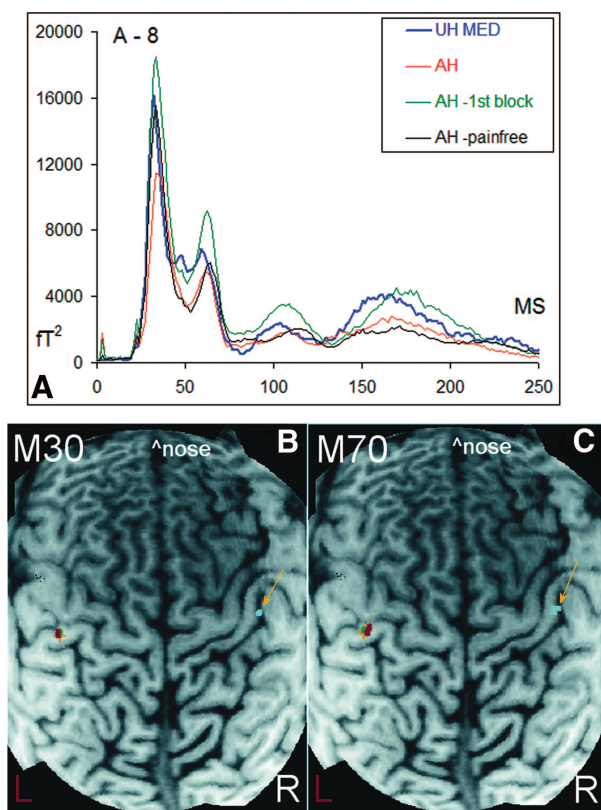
and C present a one-dimensional image of the MRI of patient A-8 with all four dipoles projected over both hemispheres at M30 and M70, respectively. The UH dipole
